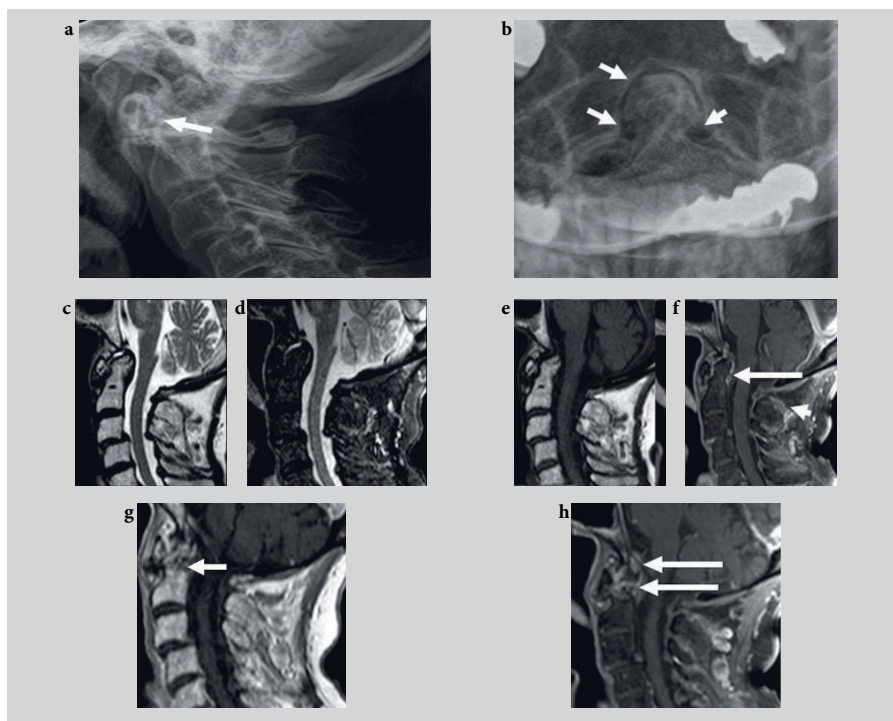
Conventional X-ray and magnetic resonance imaging (MRI) of the cervical spine of a patient with rheumatoid arthritis. Upper row: (a) X-ray of the cervical spine in lateral projection shows signs of subluxation (arrow) of the C1/C2 junction; (b) open mouth X-ray of the dens axis shows several erosions (arrows). Middle row: (c) sagittal short tau inversion recovery (STIR); (d) T2-weighted; (e) T1-weighted pre-contrast; (f) T1-weighted post-contrast 1.5T MRI of the upper cervical spine. Lower row: (g) T1-weighted pre-contrast; (h) T1-weighted post-contrast MRI of a neighboring section of the same patient (arrows in the post-contrast T1w images) and marginal erosions of the dens axis (open arrows). Post-contrast images show enhancing synovitis around the dens axis (long arrows). Furthermore, erosions are seen in the dens axis (short arrows).
